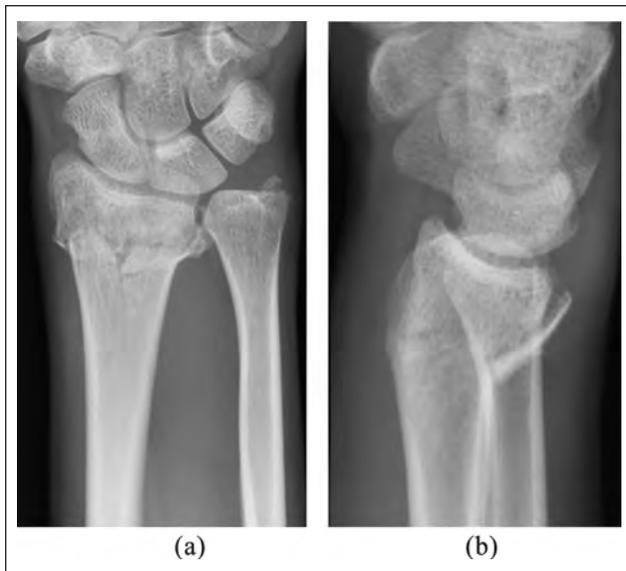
Preoperative radiographs of a typical extra-articular distal radius fracture amenable to fixation with purpose-designed threaded pins: (a) posteroanterior view and (b) lateral view.
